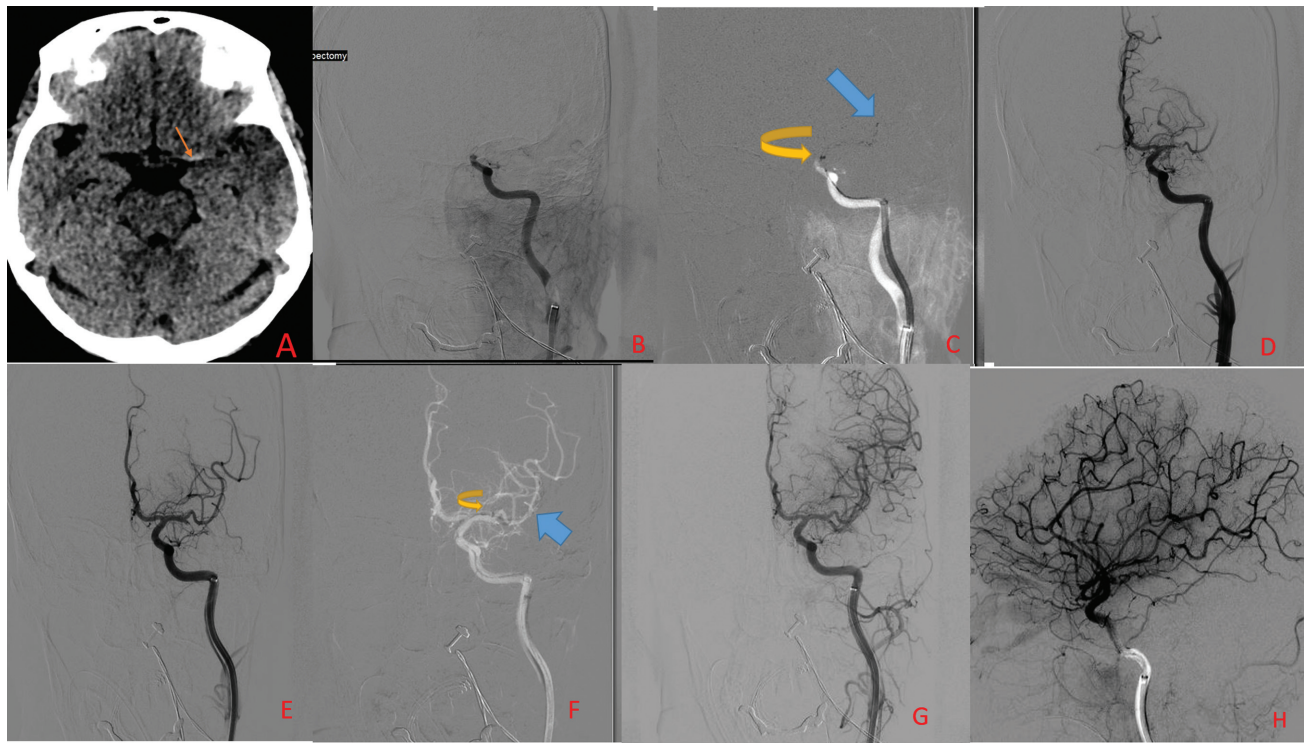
A patient with an ictus of 6 hours presented in casualty with sudden onset right hemiparesis, slurring of speech, and restlessness. On examination, the National Institutes of Health Stroke Scale (NIHSS) score was 15. The patient had diabetes mellitus (DM) and hypertension (HTN) with no cardiac comorbidities. The patient was taken for mechanical thrombectomy under general anesthesia. (A) Noncontrast computed tomography (NCCT) axial image showing dense middle cerebral artery (MCA) sign on the left side (shown by arrow). (B) Digital subtraction angiography (DSA) anterior-posterior (AP) image of left internal carotid artery (ICA) run shows T occlusion. (C) (Demonstration of Solumbra technique) Roadmap of left ICA angiogram, long sheath, aspiration catheter (yellow curved arrow), the stent (thick blue arrow Trevo 4 × 30 mm). (D) Left ICA run after 1st Solumbra pass showing minimal improvement in recanalization (modified thrombolysis in cerebral ischemia [mTICI] = 1). (E) DSA of left ICA after 2nd Solumbra pass showing recanalization of the superior division of M2 MCA and left M1 MCA (mTICI = 2a). (F) Roadmap image of left ICA demonstrating 3rd pass of Solumbra technique with stent retriever (shown by thick blue arrow) in the inferior division of M2 MCA with the good opening of struts, aspiration catheter (shown by yellow curved arrow) at left MCA bifurcation level. (G and H) AP and lateral view of left ICA run show complete left MCA territory recanalization (mTICI = 3).
